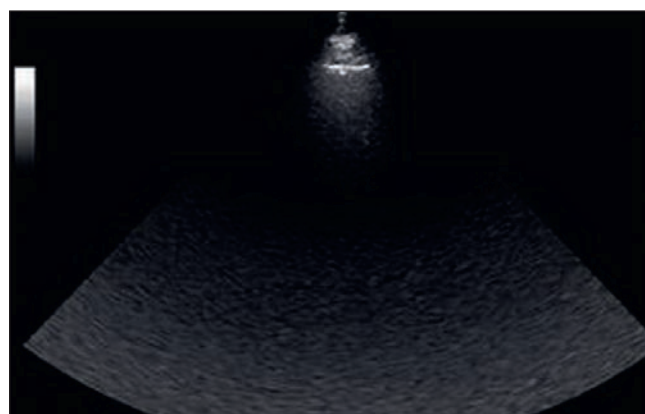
Ultrasound image of unchanged lung tissue (from the personal archive of G.V.Nekludova)
